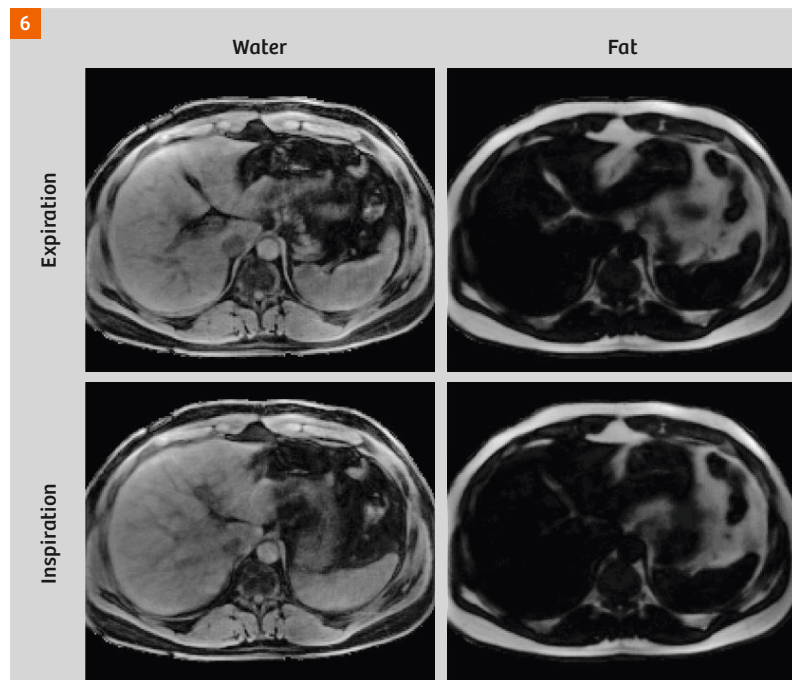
Water-only and fat-only inspiratory and expiratory 4D-MR images of a pancreas cancer patient obtained using a 4D Dixon FLASH acquisition.
